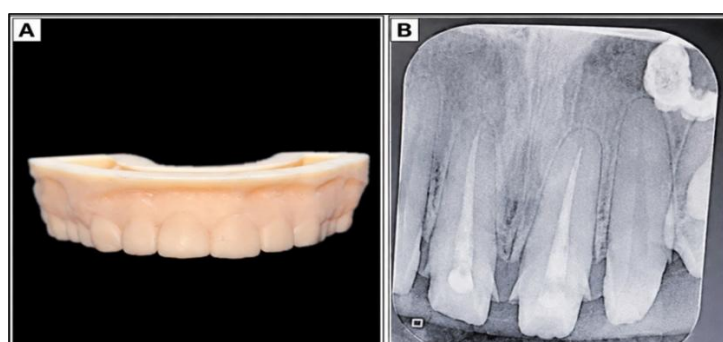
Mock-up (A) Additively manufactured resin model (B) Preoperative periapical radiograph
